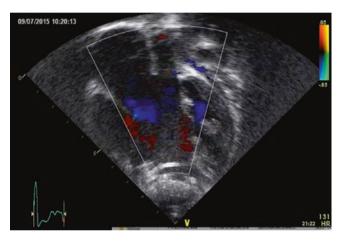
Echocardiographic image: unbalanced AVSD (hypoplastic LV), apical four chambers view, colour Doppler
